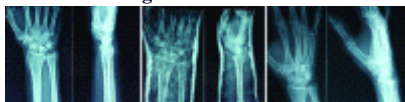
Pre Op, Post Op and 6 month follow up X-rays of a
